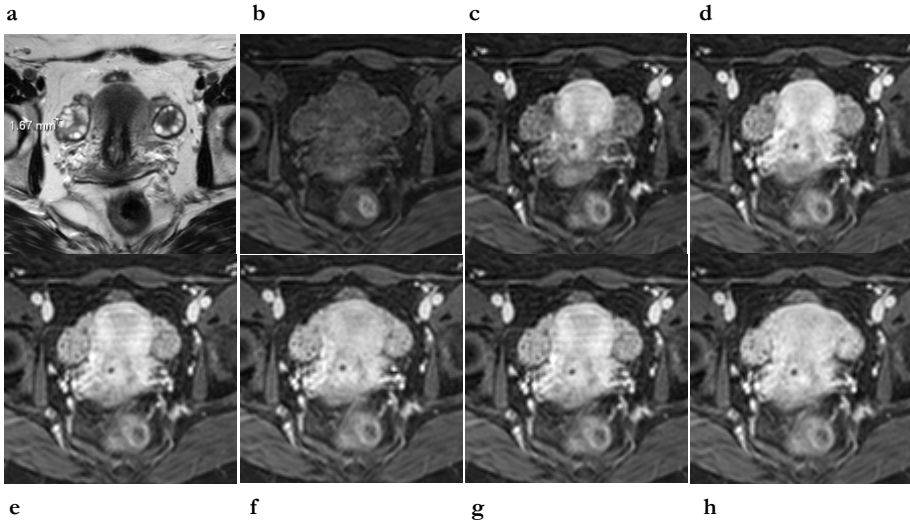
Transaxial T2-weighted TSE scan (a), and T1-weighted fat suppressed GE scans before (b) and 0.5 (c), 1 (d), 2 (e), 3 (f), 4 (g), and 5 (h) minutes after intravenous injection of contrast medium in the transaxial plane. The 1.67 mm measurement is the thickness of the peripheral rim at the lateral border of the ovary on the right side. This rim can still be identified on the fat suppressed GE images. Note the fast and strong contrast enhancement of the uterine myometrium (in this case, the uterus is in-between the polycystic ovaries), demonstrating high perfusion. Contrast enhancement is relatively intense in the ovarian stroma as compared to gluteal muscle tissue (visualized in the bottom parts of the images), but not as fast and intense as in the myometrium. The peripheral rims seem to enhance to a similar extent as the stroma in the inner parts of the ovaries.
